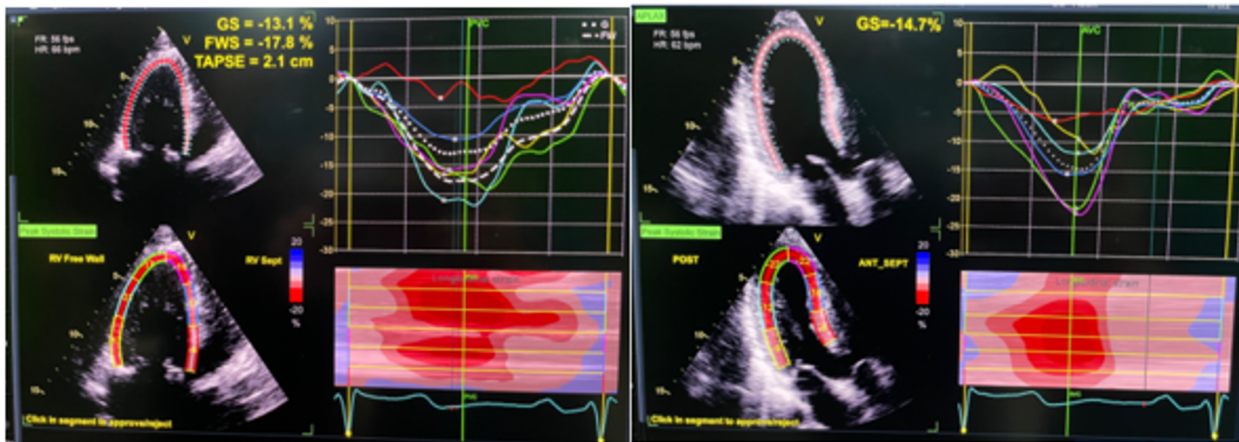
Speckle tracking echocardiography showed RV Free Wall GLS -17,8% after BPV (left) and LV GLS -14,7% after BPV (right).
